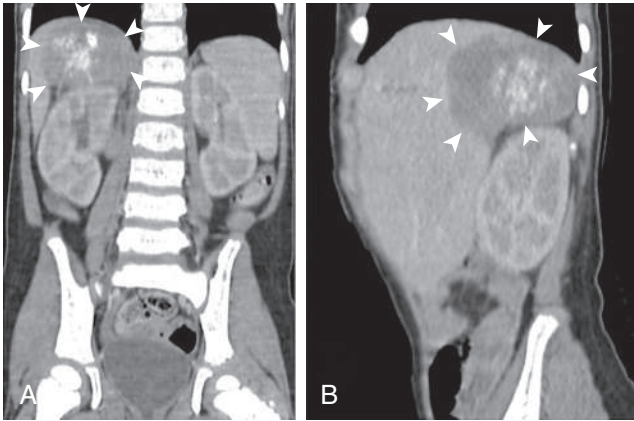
Neuroblastoma. CT images of the abdomen with coronal (A) and sagittal (B) reconstructions showing a large low-density tumor in the right suprarenal region (arrowheads). Note the neoplastic calcifications inside the mass. (From Mota EB, Penna CRR, Marchiori E. Metastatic dissemination of a neuroblastoma. *J Pediatr*. 2017;189:232–232.e1. Fig. 3.)
